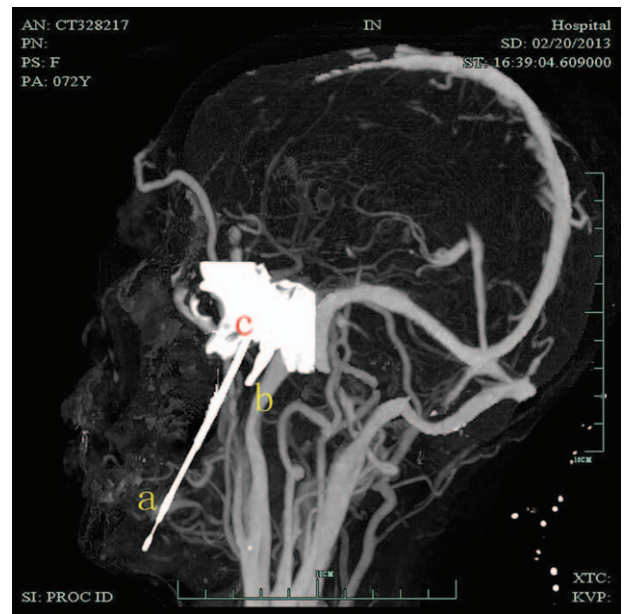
3D-CTA image. (a) Submandibular trajectory puncture needle, (b) carotid artery, (c) foramen ovale.
